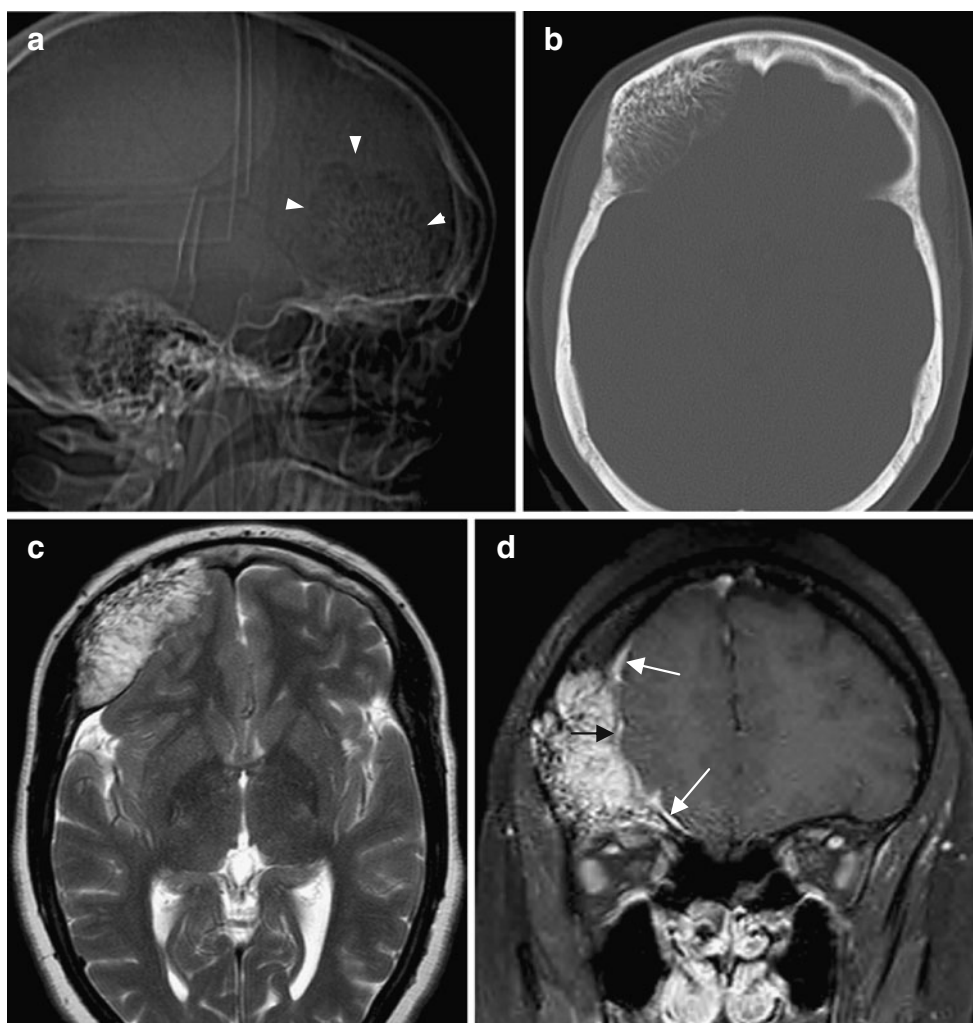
Hemangioma in a 30-year-old woman who presented with worsening headaches, blurred vision, and right proptosis. a Scout CT showing the radiating “honey-comb” trabecular pattern of this frontal well-circumscribed lesion (*arrowheads*). b CT with bone algorithm showing an expanded lesion that erodes the inner table more than the outer table and contains radiating trabeculae with mass effect on the adjacent frontal lobe. c T2WI showing a hyperintense mass. d Contrast-enhanced coronal T1WI also showing enhancement of the mass and a dural tail sign (*white arrows*). The *thin hypointense line* denotes the epidural space, thus suggesting that the dural enhancement is reactive rather than infiltrative (*black arrow*). Note that the lesion reveals heterogeneous intensities in all MRI images due to the bony trabeculae
